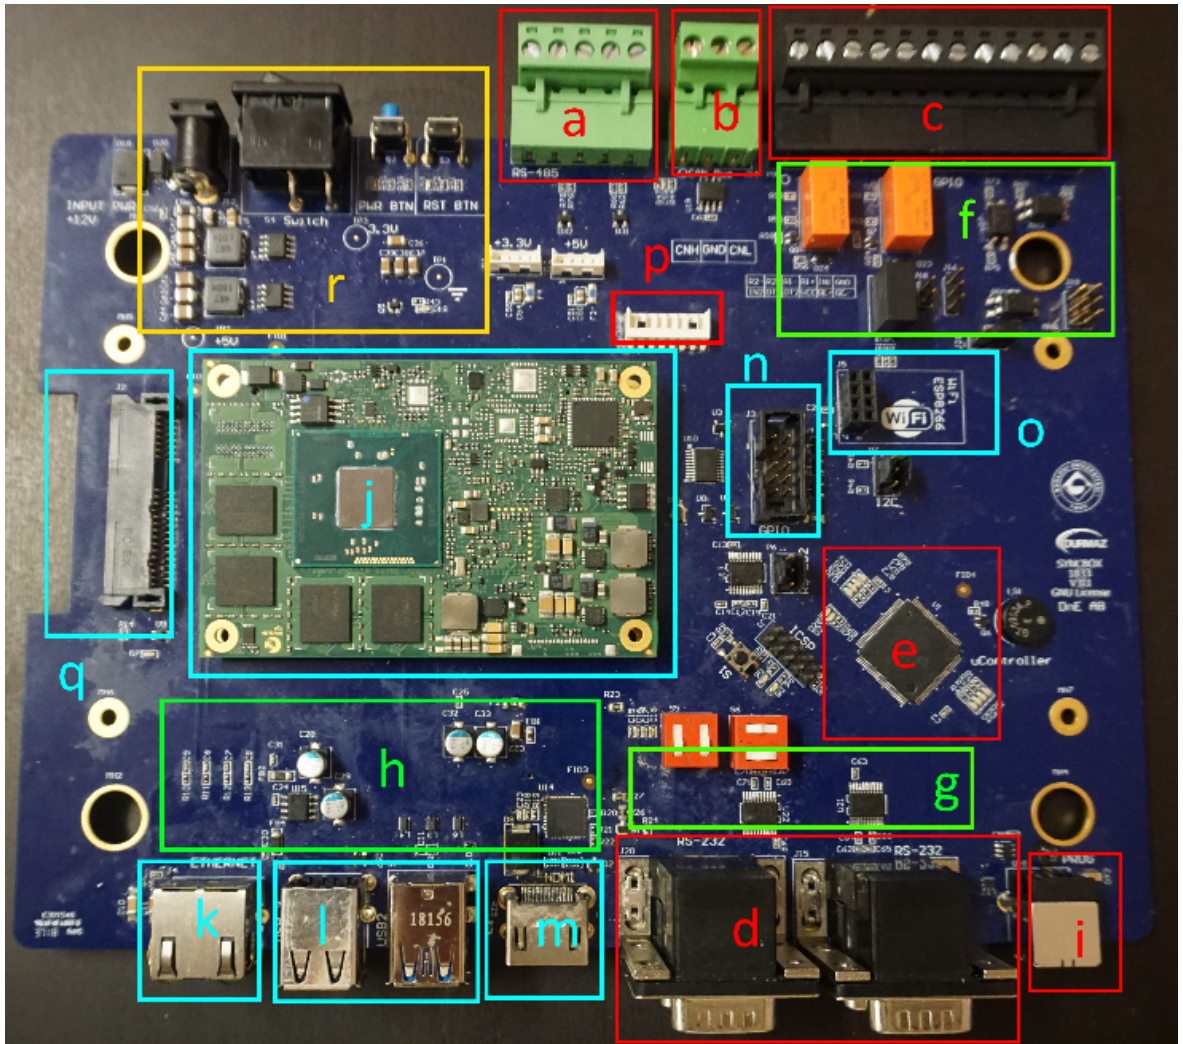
Implemented SyncBox device. The details of each unit are listed in Table 2. X-ray systems could use a variety of communication protocols. SyncBox has all the generic communication ports ready for future applications.
